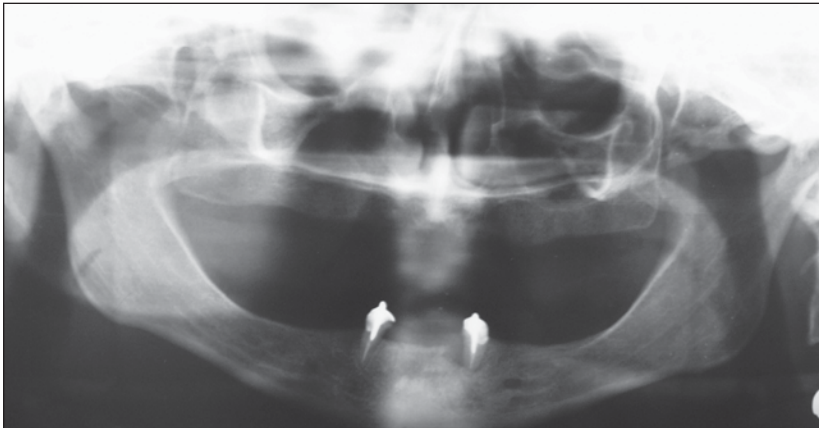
Panoramic radiograph 1 week before the placement of the implants.
